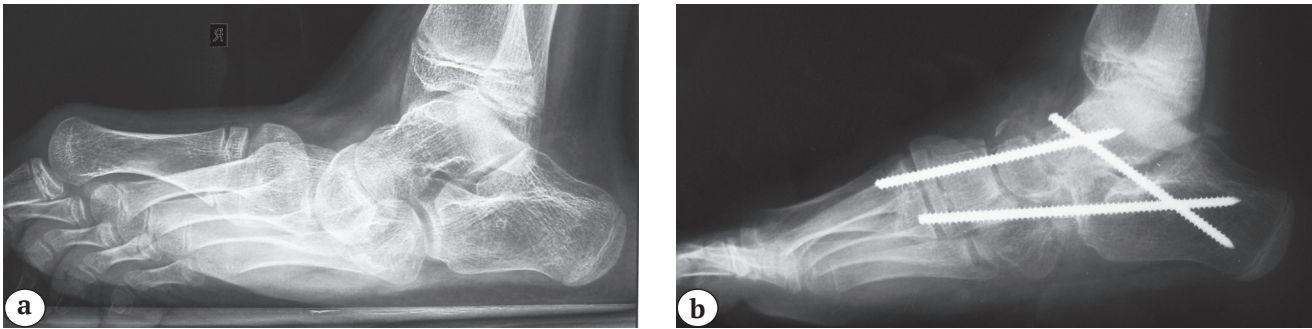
X-ray images of patient 13 y.o.:
